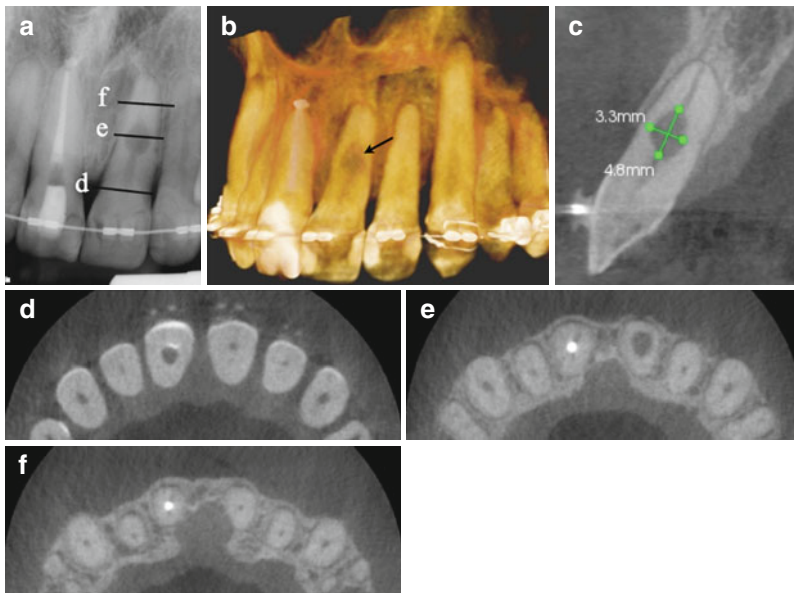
Patient was referred for evaluation and treatment of an internal resorptive defect on tooth number 9. (a) Periapical radiograph of tooth number 9. The 3 lines correspond to the axial section views in (d), (e), and (f). (b) 3D reconstruction of maxillary anterior teeth demonstrating the internal resorptive defect (*black arrow*). (c) Sagittal view of tooth number 9 with the 3.3×4.8 mm measurement of the defect. (d), (e), and (f) are axial views of tooth number 9. Note the normal canal anatomy coronal and apical to the defect (d, f). The maximum width of the defect is demonstrated in axial view (e)
